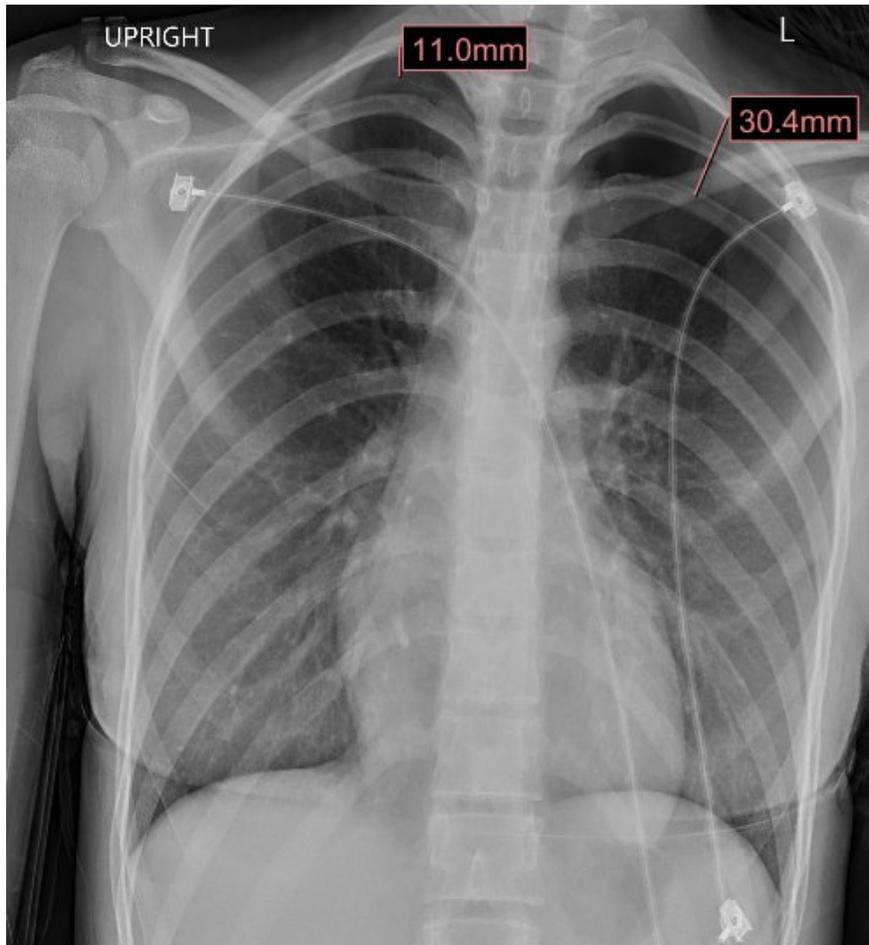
Chest radiograph from prior admission showing moderate sized pneumothorax
